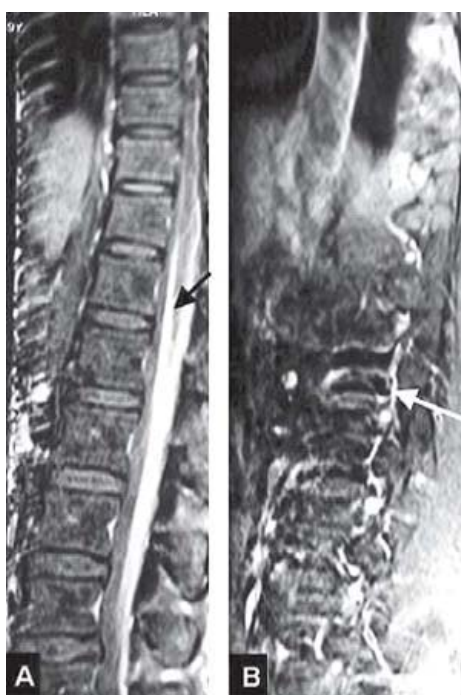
Contrast enhanced MRI in a patient with spinal pachy arachnoiditis showing post-gadolinium enhancement of meninges [arrow] [A]; and nerve roots [arrow] [B] in a patient with spinal pachy arachnoiditis
